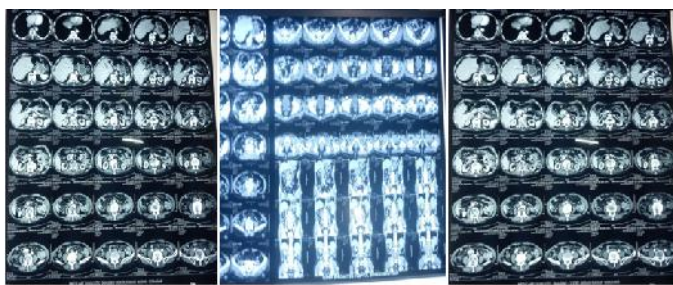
Pre-operative CT scan showing Growth at Antrum, Pylorus And body
